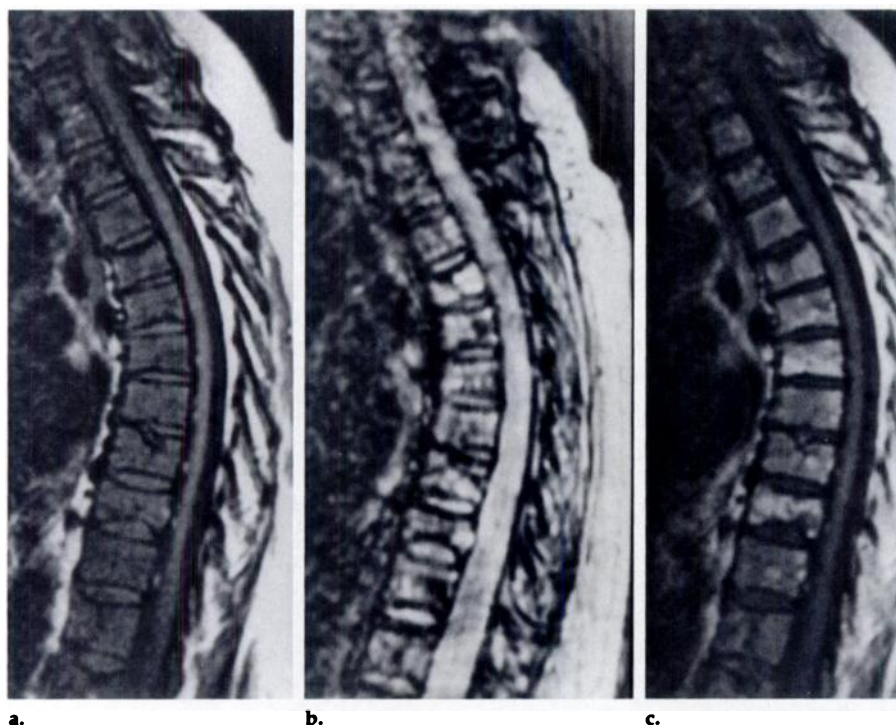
Symptomatic myeloma appearing as a diffuse pattern of marrow involvement in a 56-year-old woman. (a) T1-weighted sagittal MR image (600/20) of the thoracic spine reveals complete replacement of the fatty marrow. Note the isointense appearance of vertebral bodies relative to intervertebral disks. (b) GRE image (250/20, 20° flip angle) reveals diffuse inhomogeneous signal hyperintensity throughout the thoracic spine. (c) T1-weighted postcontrast image (600/20) reveals diffuse enhancement of the marrow. The intervertebral disks are now hypointense relative to the enhanced vertebral bodies.
